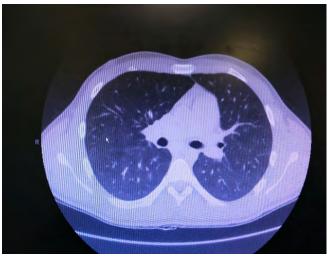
Chest CT showing an enlargement of the pulmonar artery.
